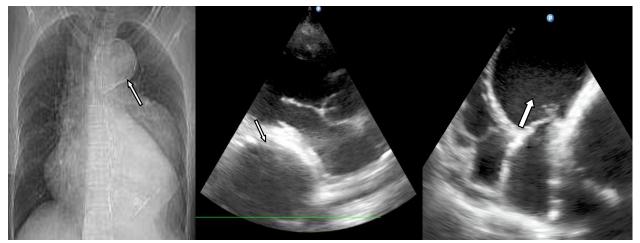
X-ray showing cardiomegaly with aneurymal arch
